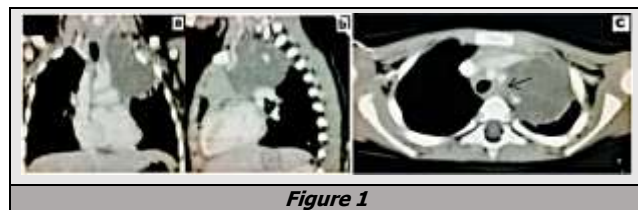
Contrast enhanced (a)coronal, (b)sagittal and (c) axial CT sections at the level of thorax show Cystic lesion with thin internal septations in superior mediastinum on left side extending into neck superiorly causing splaying of left subclavian and common carotid arteries (black arrow) and stretching of left brachiocephalic vein and also minimal compression collapse of adjacent lung parenchyma (*).
